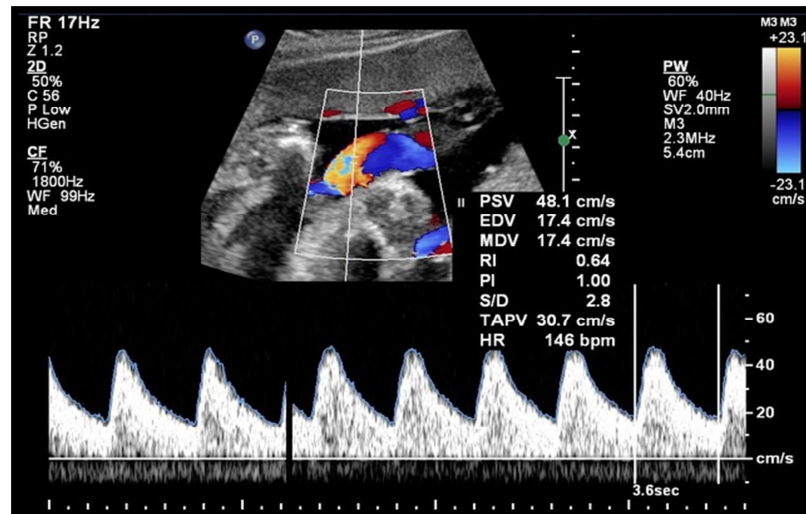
NORMAL UA DOPPLER TRACE
